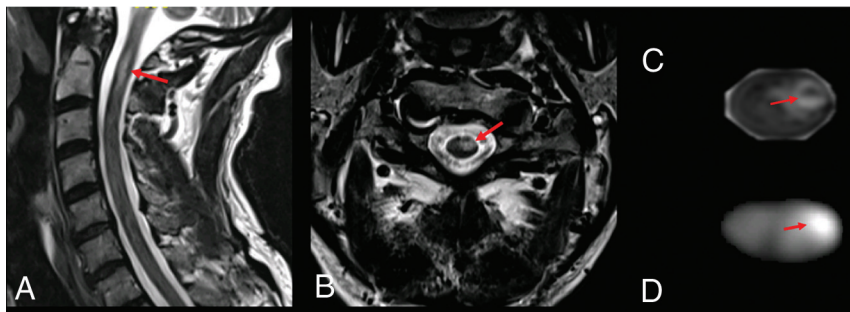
Postoperative MR imaging findings 1 day after cervical cordotomy. *Red arrows* indicate the cordotomy ablation. *A*, Sagittal T2-weighted imaging. *B*, Axial T2-weighted imaging. *C* and *D*, Axial diffusion trace images.
